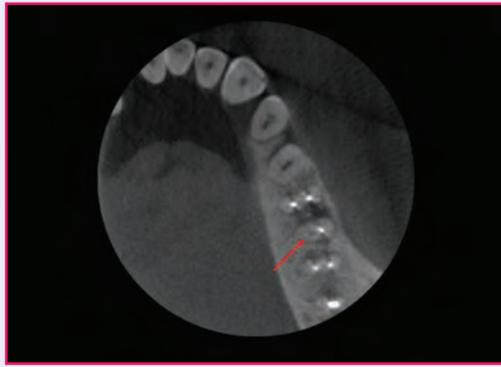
Axial view of CBCT
